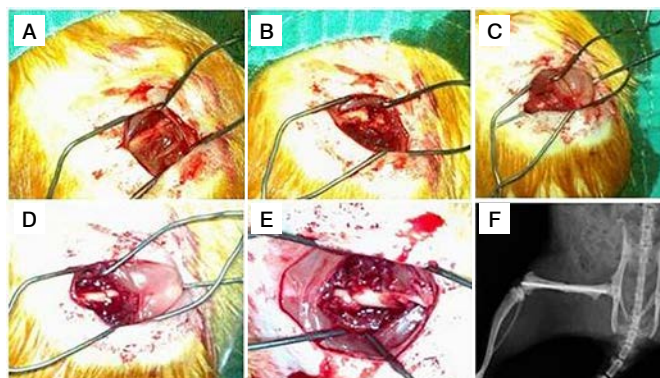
(A) An image of the femur after retraction of the soft tissues; (B) After the transverse fracture was obtained; (C) After placing an antegrade intramedullary K-wire from the fracture site to the knee; (D) Retrograde movement of the K-wire after reducing the fracture; (E) The last image of the fracture after pushing the K-wire inside the bone; (F) The postoperative roentgenogram of the fracture.
